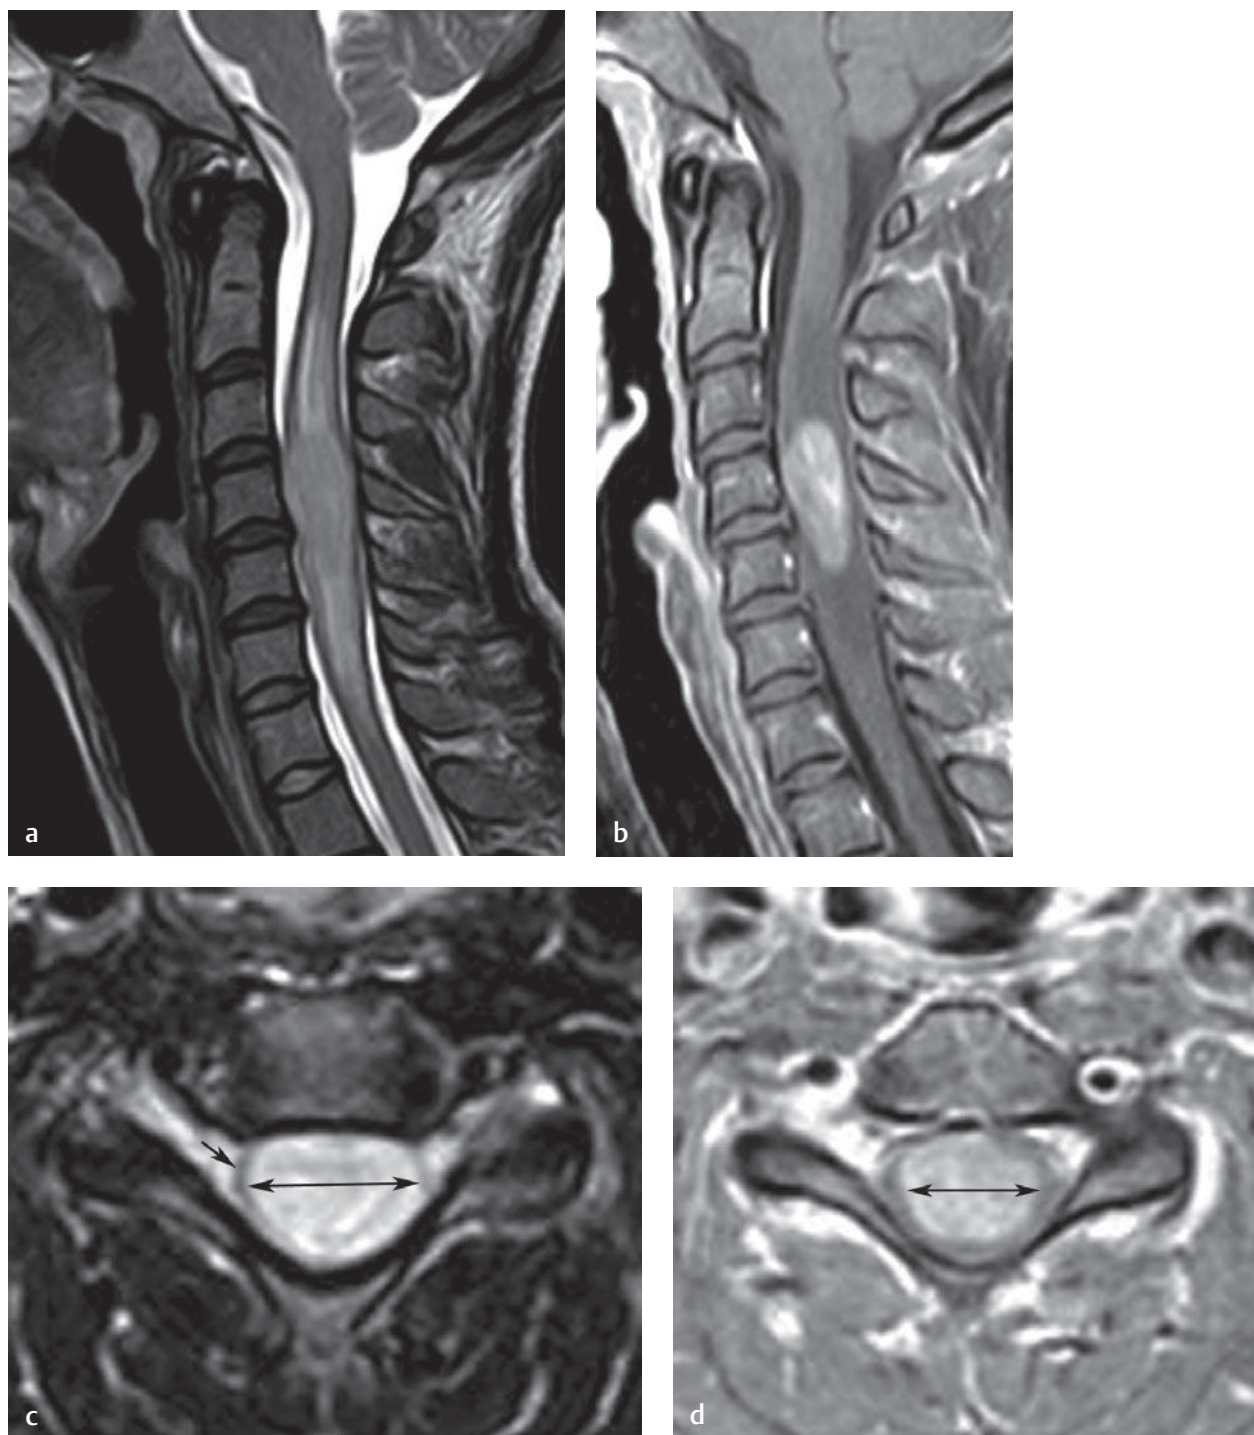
Cervical ependymoma. (a) A sagittal T2-weighted image shows a large cervical ependymoma centered at C4-C5 but with cord signal change extending from C2 to C7. (b) A sagittal postgadolinium T1-weighted image shows that the tumor is located at C4-C5 and that the signal change extended from C2 to C7 shown in (a) represents edema proximal and distal to the lesion. (c) An axial T2-weighted image shows that the lesion (between *arrowheads*) is located within the spinal cord, which is seen as a thin sliver of low signal intensity surrounding the lesion (*arrow*). (d) An axial postgadolinium T1-weighted image shows similar findings with enhancement of the tumor.[†]
